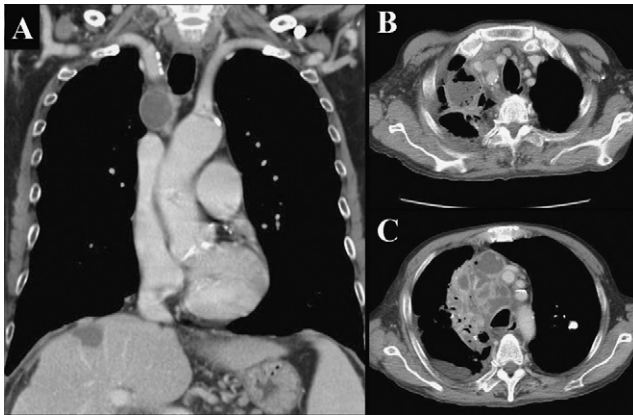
(A) Chest CT before bronchoscopy showing a hypodense nodule near the trachea. (B and C) Chest CT one day after admission showing loculated right pleural effusion, abscess in the right upper lobe, and multiloculated mediastinal abscess.
